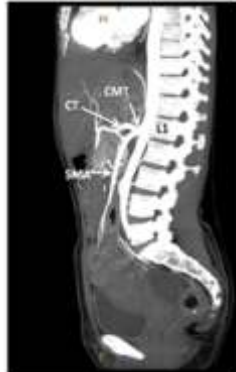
MIP (Maximum intensity projection) image depicting the origin of CMT (celiacomesenteric trunk), CT (celiac trunk), SMA (superior mesenteric artery).
